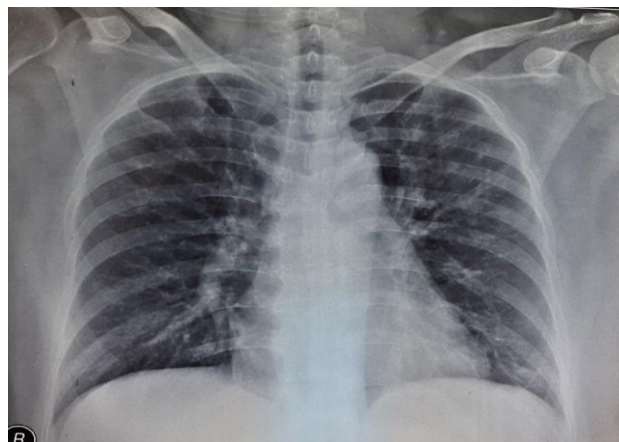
Chest X-ray of the patient revealed no abnormality.
